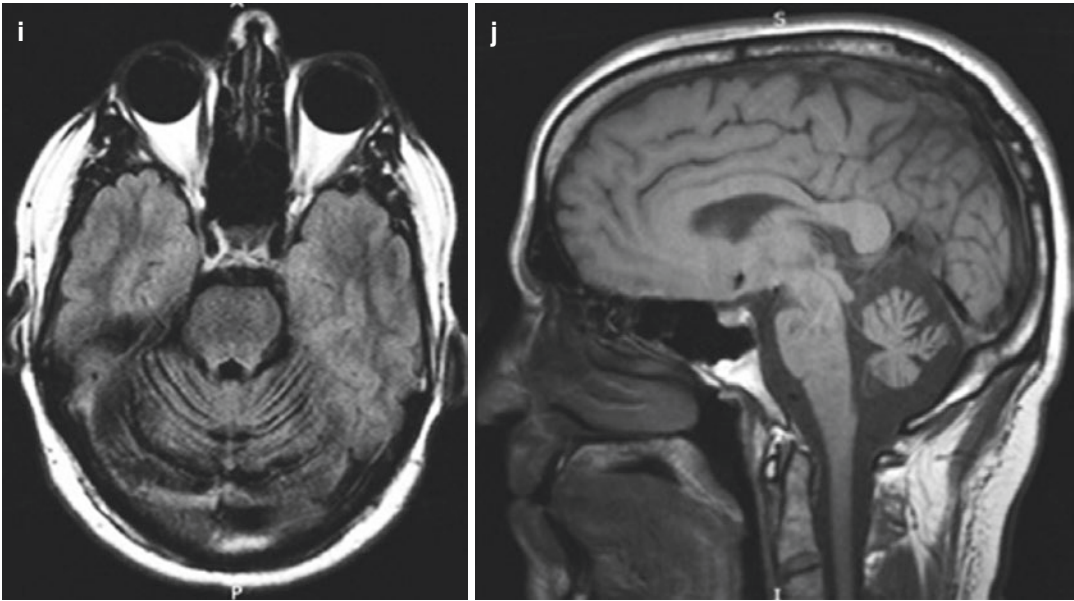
MRI findings in paraneoplastic encephalitis and subacute cerebellar degeneration
